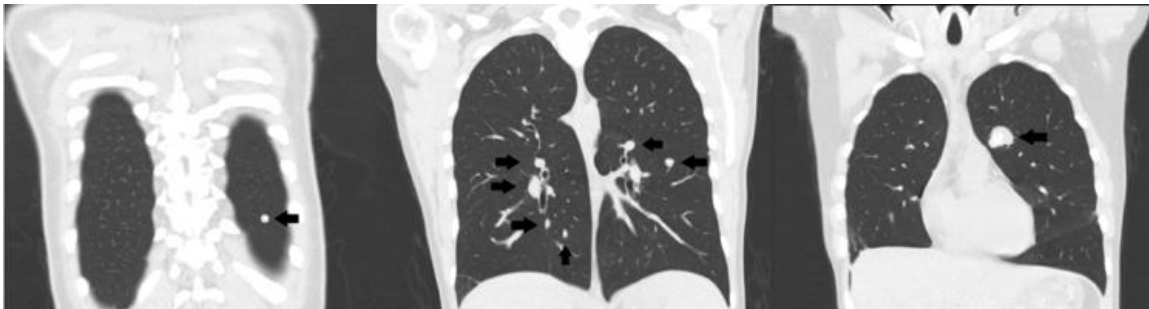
Pre-operative lung computed tomography (CT) scan for 1st patient subjected to IVLP showing numerous bilateral pulmonary sarcoma metastases as denoted by arrows
